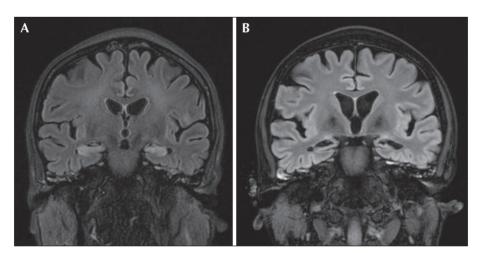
(A) Coronal FLAIR MRI on Day 38 of presentation demonstrating increased T2/FLAIR signal intensity over bilateral mesial temporal regions. (B) Coronal FLAIR MRI on Day 80 of presentation demonstrating resolution of the increased T2/FLAIR signal intensity and development of bilateral mesial temporal sclerosis/atrophy.
